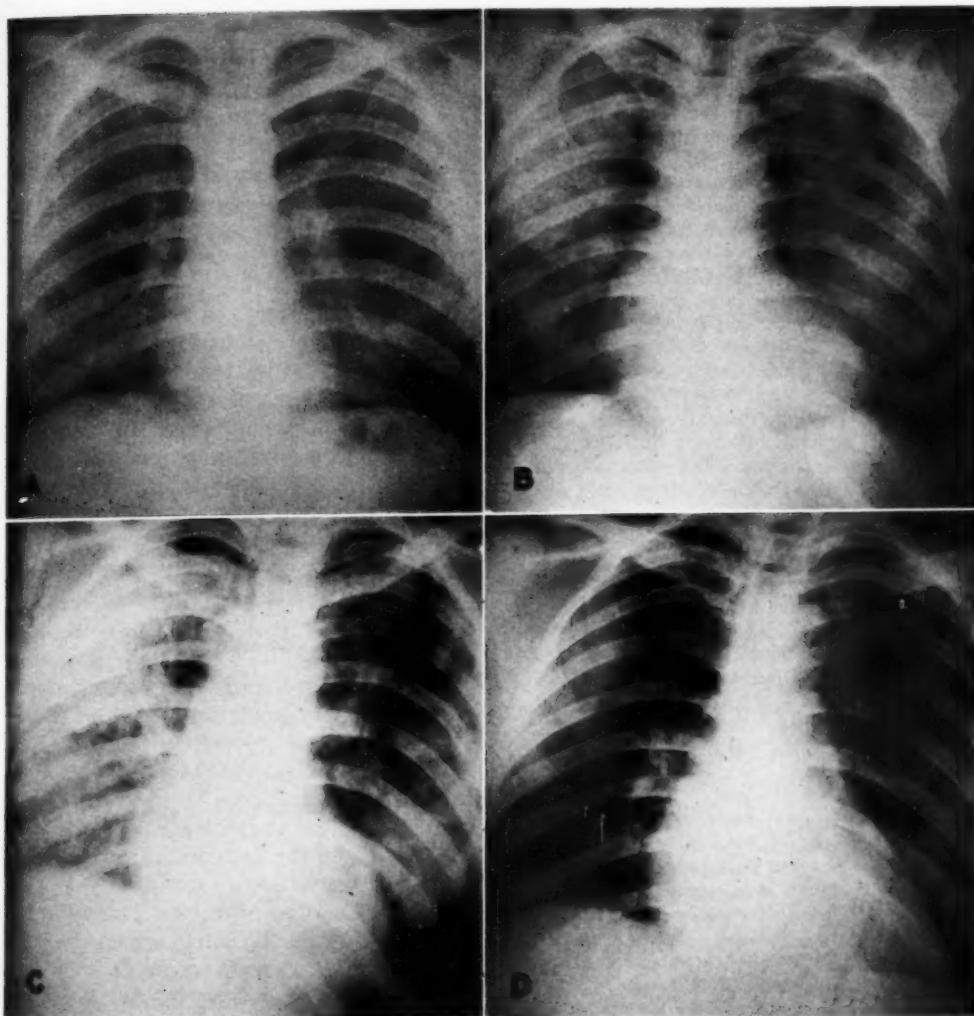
A. Roentgenogram of the chest on the third day of illness, demonstrating slight increase in peribronchial markings in both lower lungs.
